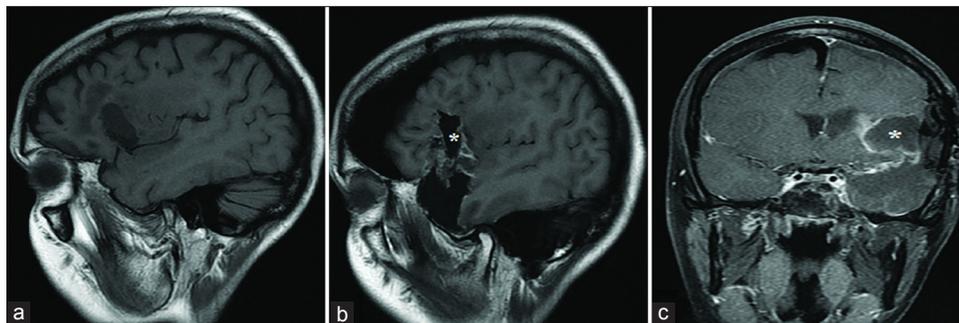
Pre- and post-operative magnetic resonance imaging of the first patient's recurrent left insular glioma, glioma resection, and temporal lobectomy. (a) Non-contrast, T1-weighted sagittal image highlights the patient's previous resection cavity. (b) Sagittal and (c) coronal MR images demonstrate the patient's post-operative resection cavity as well as resection of the left anterior temporal lobe. ((*) indicates the post-operative resection cavity in all panels.)
